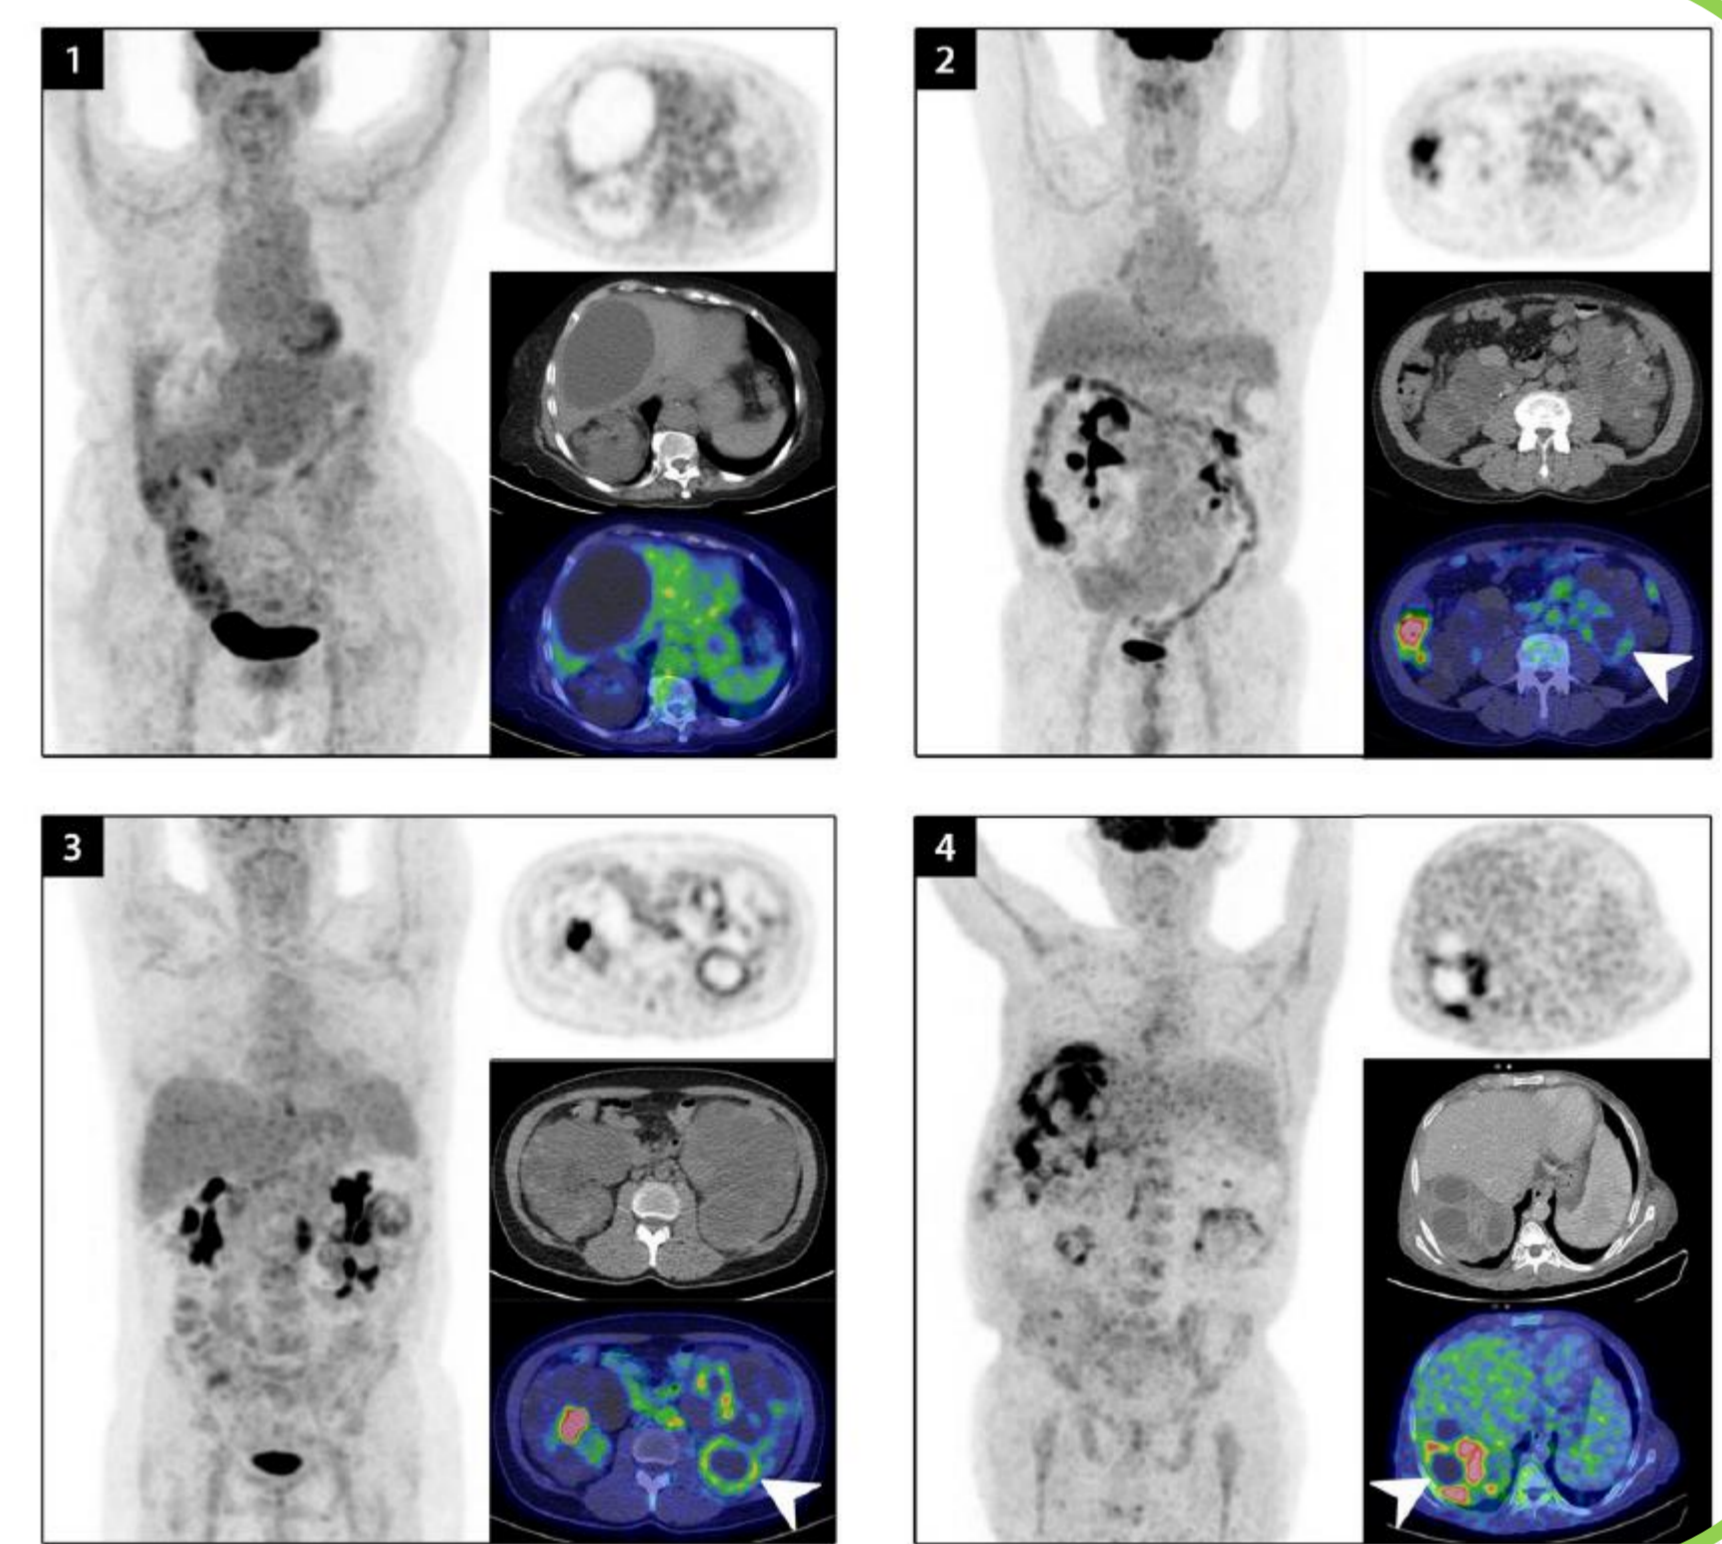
Representative [¹⁸F]FDG PET/CT images of cyst infection according to the visual 4-point scoring system. Each score on the visual 4-category scale (from 1 to 4) is represented by a panel composed of a maximal intensity projection (MIP) image of positron emission tomography (PET) post [¹⁸F]FDG; a transversal PET image of the abdomen; the corresponding transversal computed tomography (CT) image and the fusion PET/CT image. The arrowhead shows the infected cyst considered for the scoring
